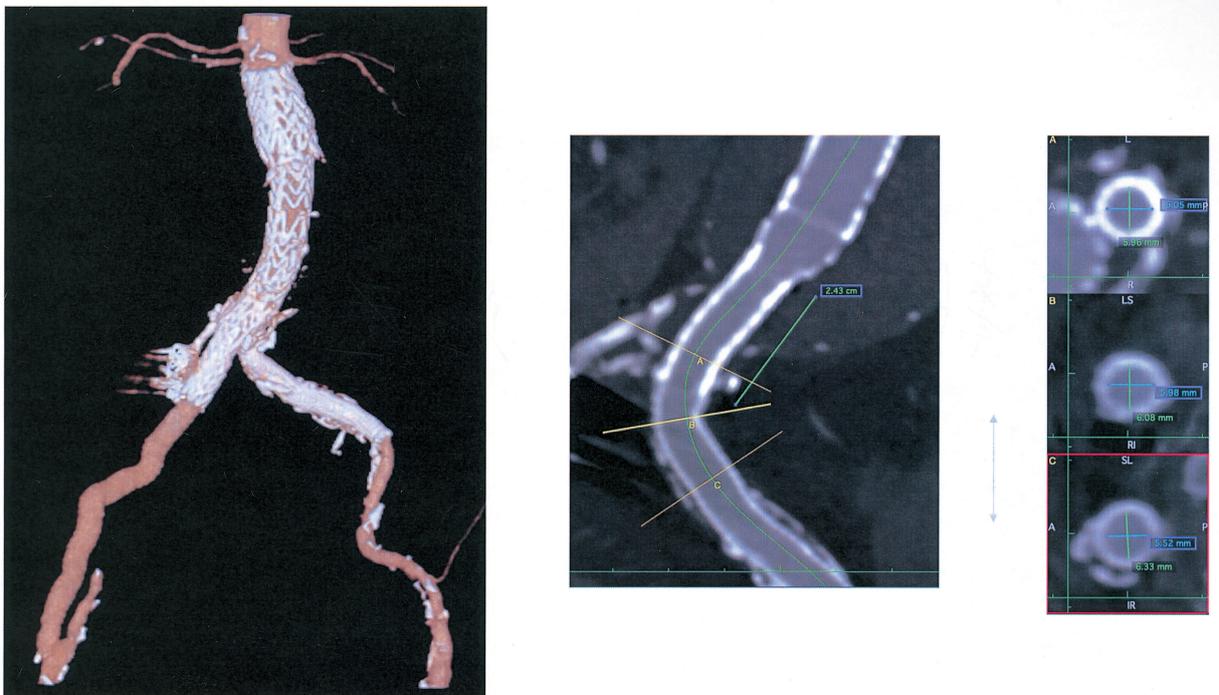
Left figure; Postoperative reconstruction of computed tomography angiogram revealed no endoleak and patency of the endoconduit. Right two figures; Sagittal section of computed tomography angiogram showed the most proximal part of the endoconduit was protruded about 2 cm into the aorta. There was no stenosis in the overlapped endoconduit.
